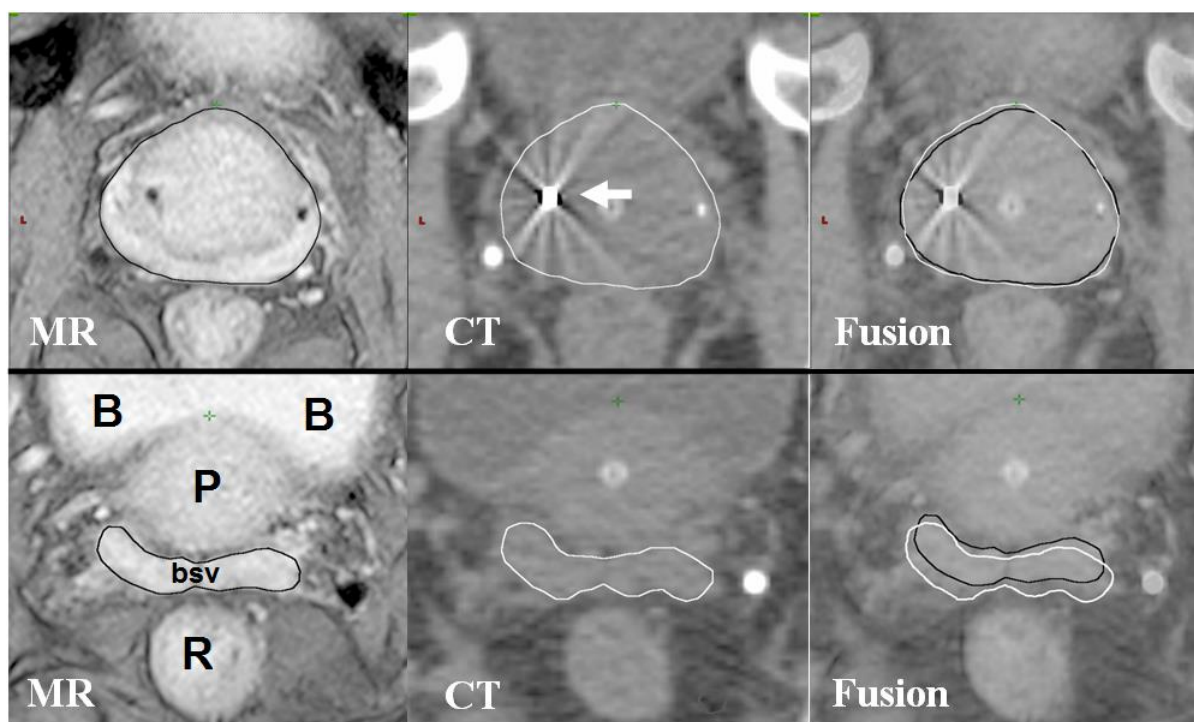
MR and CT fusion for prostate contouring.
